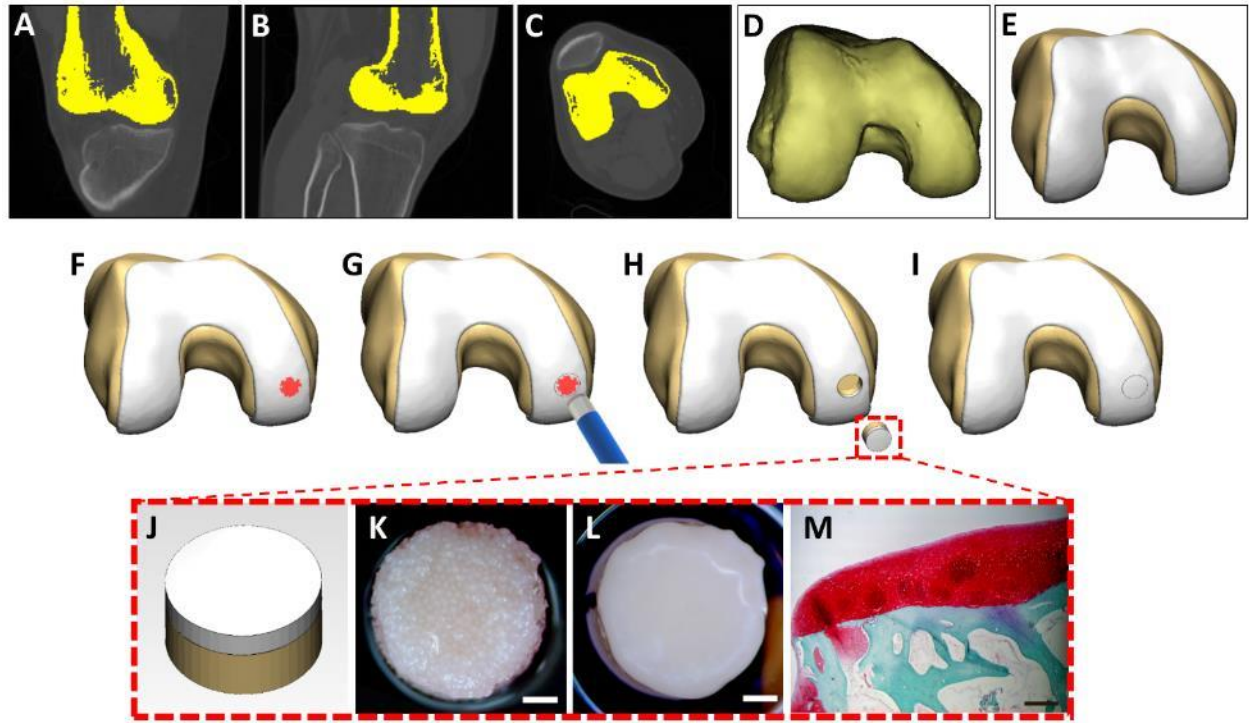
Generating personalized osteochondral allografts. Implantation of an osteochondral rather than cartilage-only allograft is necessary for cartilage defect diseases accompanied by an underlying bone lesion, such as osteochondritis dissecans. Natural allografts have the drawbacks of not fitting the geometry of a host knee and are of limited availability. To meet the clinical demand and provide a potential solution for osteochondritis dissecans lesions, here we present a proof-of-concept methodology generating personalized allografts using PA-MCTs and decellularized bone tissues. Engineered allografts were designed to fit the patient's dimensional information of the mimicked diseased knee joint in the following 4 steps. (i) Generating a healthy osteochondral model of a distal femur (A–E): regions of the femur bone were segmented from computed tomography images of a human joint (A–C); the distal femur bone was volumetrically 3D reconstructed (D); and a cartilage layer was created from the bone surface (E). (ii) Cartilage defect creation and allograft design (F–I): a defect was created on the weight-bearing region of the medial condyle (F, shown in red), and chondral lesion preparation was mimicked in the model (G). An
